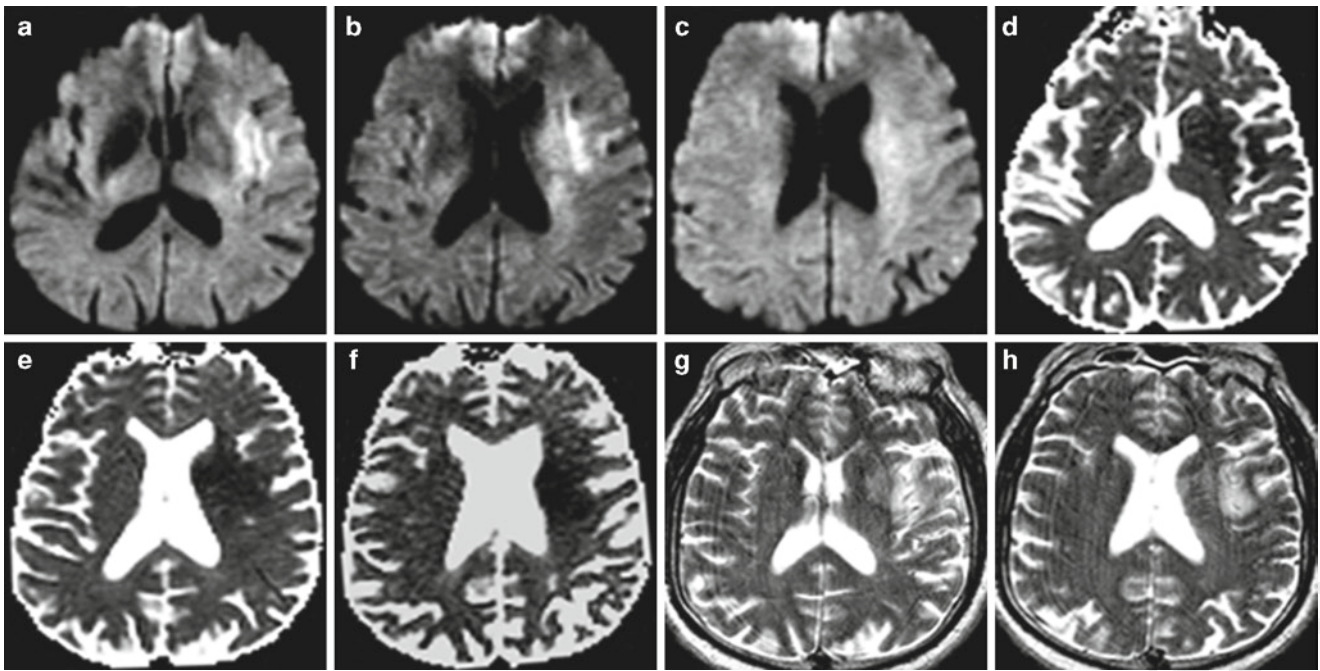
DWI reversibility. A 69-year-old man presenting with acute dysarthria and right-sided weakness who was treated with intra-arterial thrombolysis with successful recanalization of a left M1 clot 6 h after symptom onset. (a–c) DWI and (d–f) ADC images obtained prior to therapy demonstrate restricted diffusion consistent with acute ischemia
